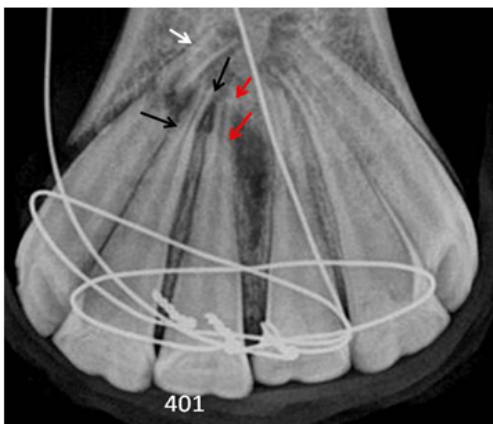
This radiograph was taken Feb. 5, 2009 showing the fixation wire around 5 incisors. The fixation to the premolars is not included in the image. The fracture fragment of 403 is observed unchanged (white arrow). The apical parts of 401 and 402 are slightly thinner (between the black and red arrows). Incisors alignment appears satisfactory.
